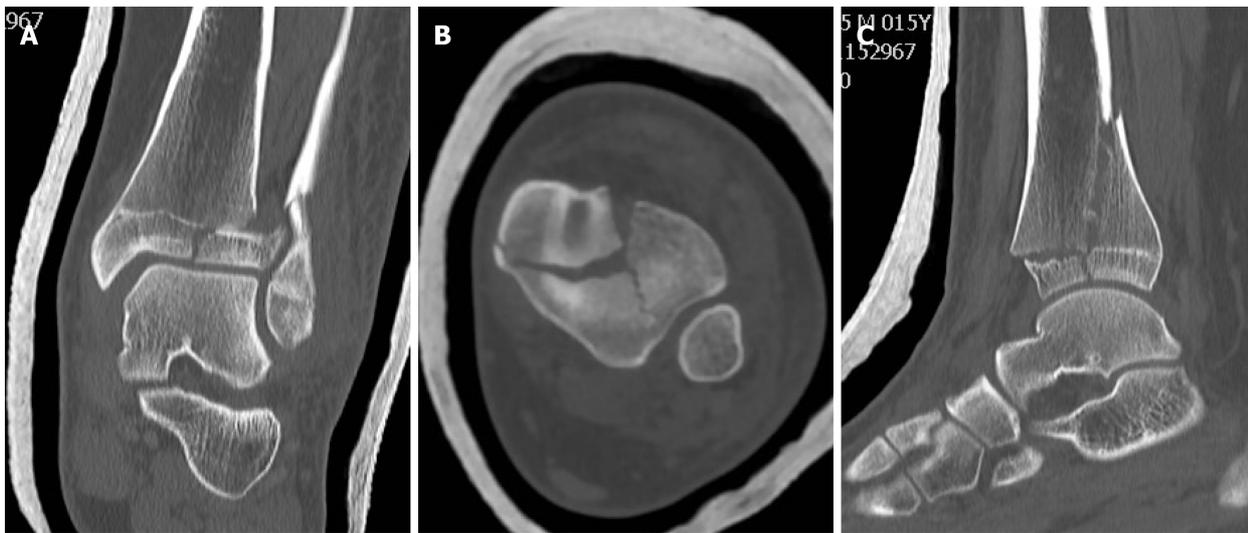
Computed tomography scan shows a triplane fracture. A: Coronal plane; B: Axial plane; C: Sagittal plane.
